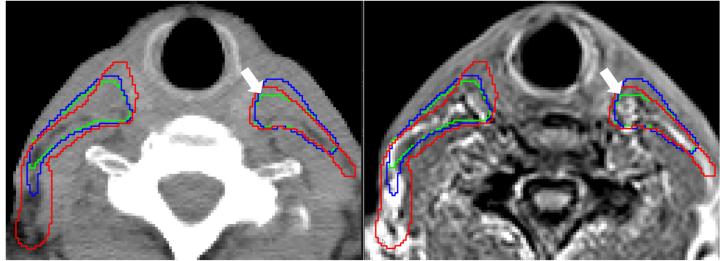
Exemplary transversal CT (left – soft-tissue-window) and MRI (right) slice (#57) of patient 1 with CT-nCTV (blue), CT-MR-nCTV (green), and man-nCTV (red). White arrows are pointing to the examples of the main difference between the predicted volumes coinciding with MRI soft tissue boundaries not contrasting in CT.
